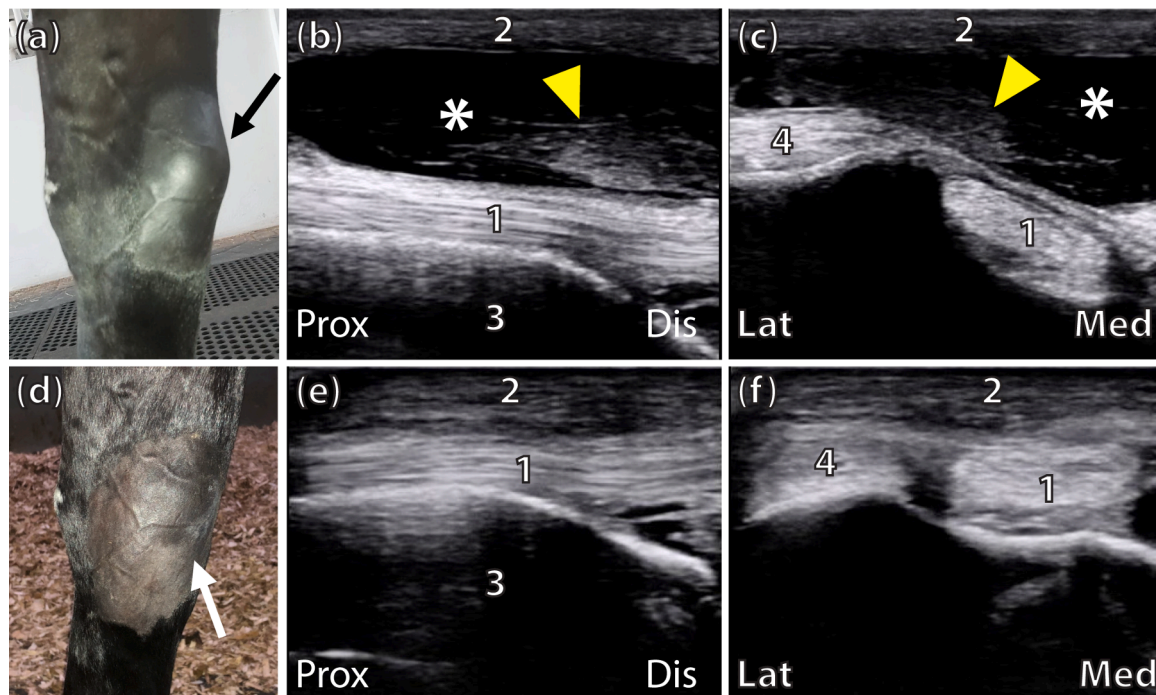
Physical appearance and ultrasonographic imaging of the right carpus following intrathecal treatment administration. After the first intrathecal injection, the distension on the affected carpus was still visible, albeit smaller than before beginning treatment (black arrow) (a). Ultrasonographic images revealed the presence of an anechoic fluid deposit (asterisk) and synovial cell proliferation (yellow triangles) on the longitudinal (b) and transverse (c) planes. After the second intrathecal injection, the distension resolved (white arrow) (d), and neither fluid deposits nor synovial cell proliferation was observed ultrasonographically (e and f). Prox = proximal; Dis = distal; Med = medial; Lat = lateral; 1 = common digital extensor tendon; 2 = skin; 3 = radius; 4 = lateral digital extensor tendon.
